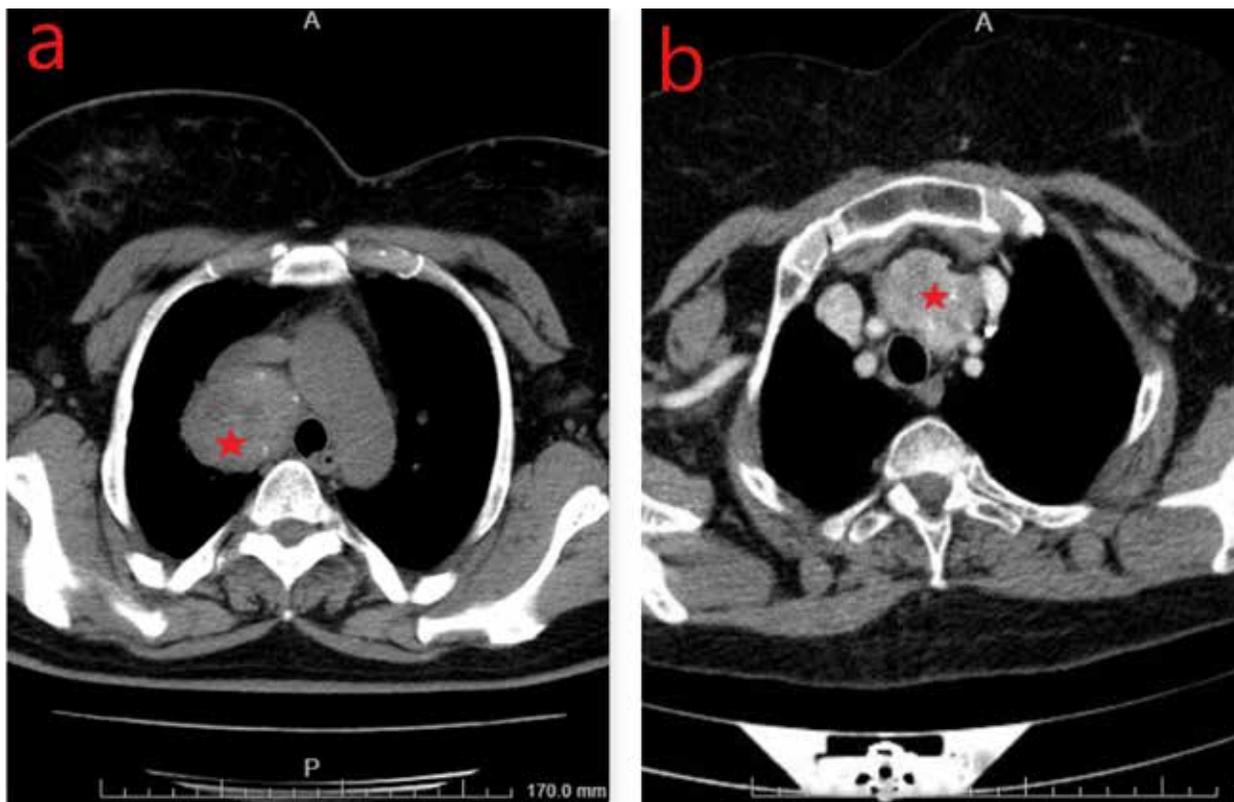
Thorax CT images of three cases. Mediastinal ectopic thyroid tissues (arrow) were located in anterior mediastinum (figure 1a), middle mediastinum (figure 1b) and posterior mediastinum (figure 1c). In these three cases, we preferred VATS procedure and no complication was seen.
